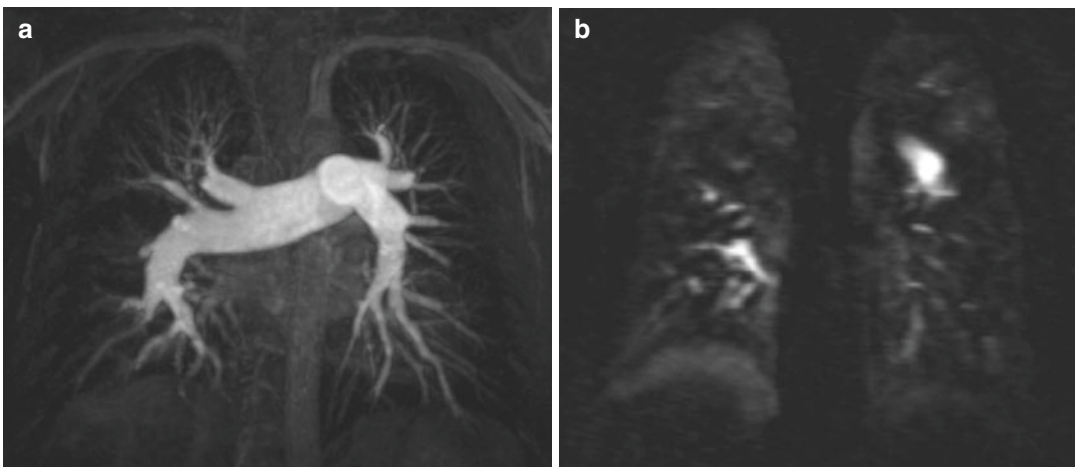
Patient suffering from PAH. Two years before this MRI examination an invasive pressure measurement revealed a mean pulmonary arterial pressure of 56 mmHg. (a) MR angiography (50 mm MIP) shows the dilated main and central pulmonary arteries and the tortuous course
